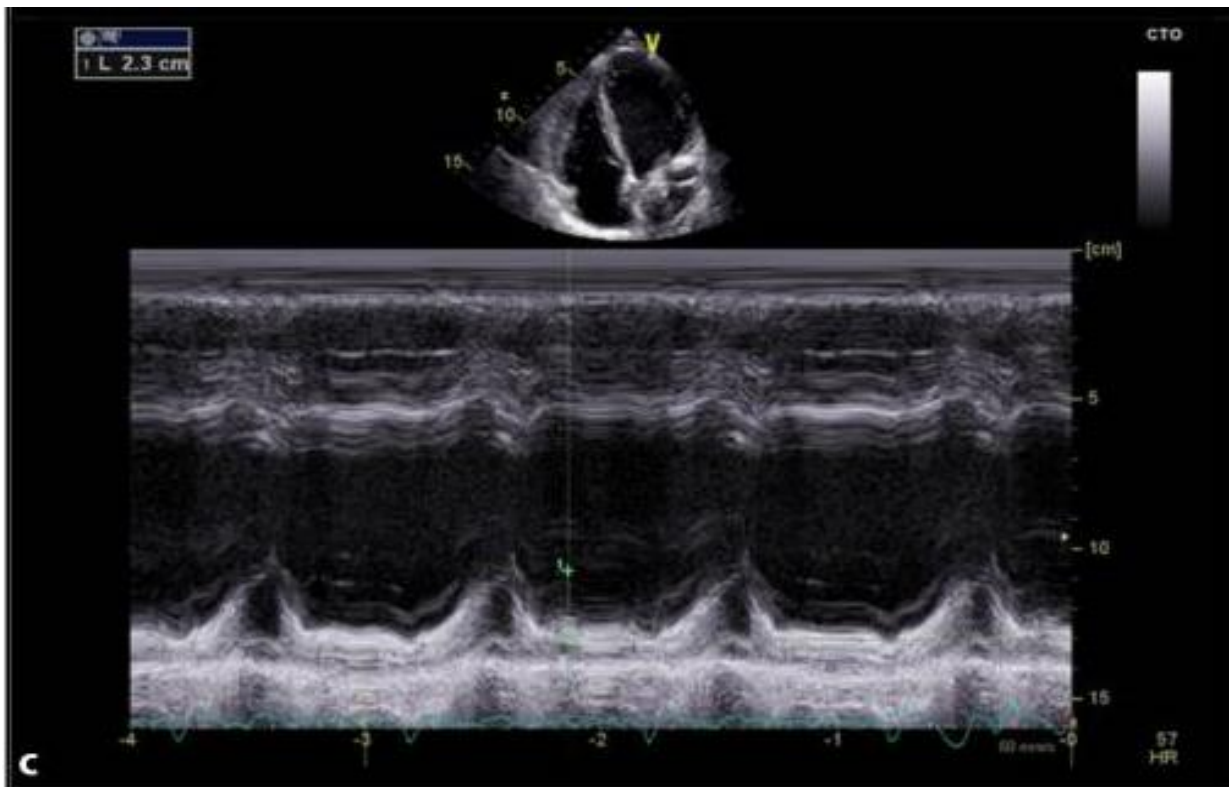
Human Tricuspid annular plane systolic excursion (TAPSE) measurement on apical four-chamber view.
